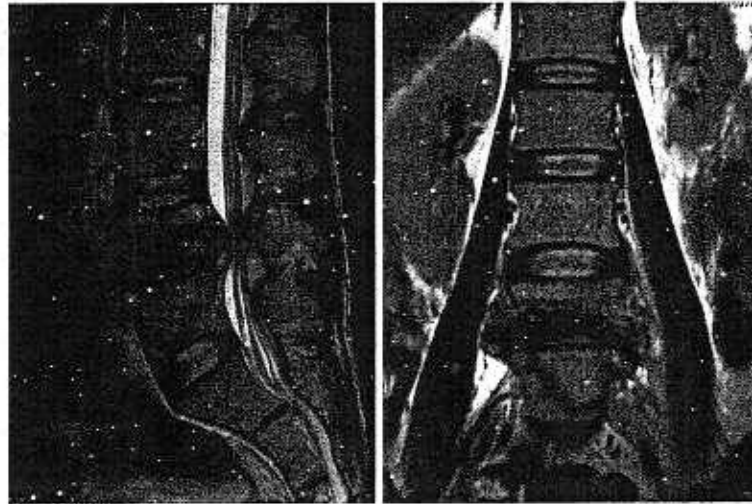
Typical MRI pictures of the TB of the spine (Courtesy of Dr. Soetomo General Hospital, Surabaya)
